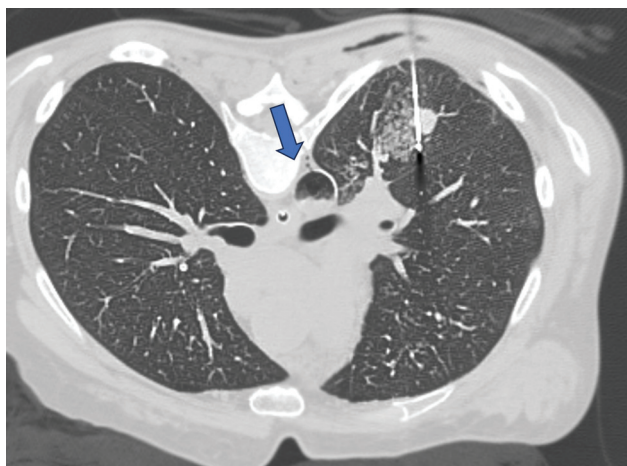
Patient developed air embolism in the aorta after percutaneous lung biopsy. (A) A small right lower lobe nodule is targeted. (B) After biopsy, perilesional hemorrhage obscures the nodule, and an air-blood level is seen in the aorta (arrow). This patient suffered from cardiac arrest while still prone in the computed tomography scanner, despite attempted resuscitation.
